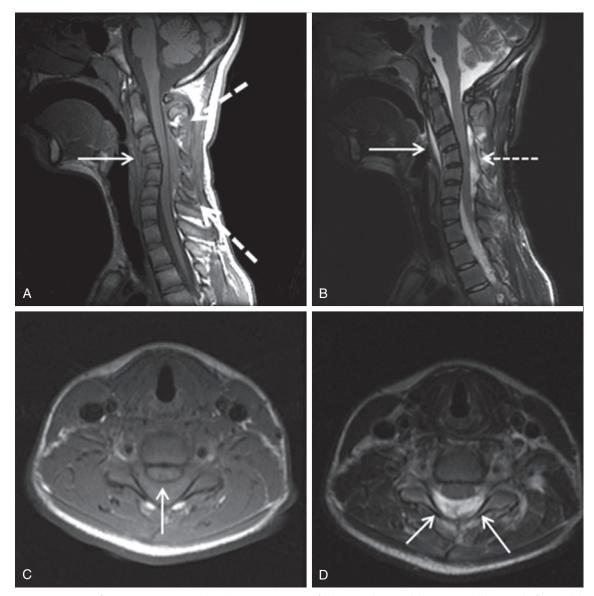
Trauma: Ligamentous flexion injury. A, Sagittal midline T₁ MR image of the cervical spine delineates marked reversal of cervical lordosis (*solid arrow*) and splaying of the spinous processes. B, Sagittal short tau inversion recovery (STIR) image at the same level better delineates the hyperintense prevertebral edema (*solid arrow*) and the hyperintense epidural hematoma (*dashed arrow*) that markedly compresses the cord. C, Axial T₁ image delineates the epidural hematoma and the compressed cord and thecal sac surrounded by the hypointense dura (*solid arrow*). D, Axial T₂ image at same level delineates the hyperintense epidural hematoma (*solid arrows*) and compressed cord.
